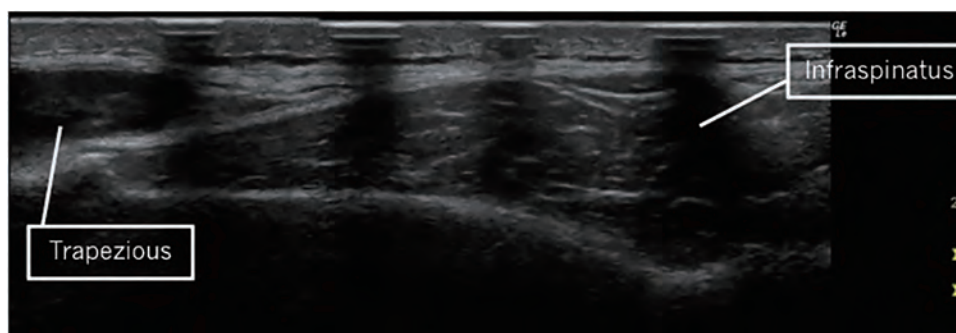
Ultrasound image of the infraspinatus muscle constructed from the series of overlapping images
